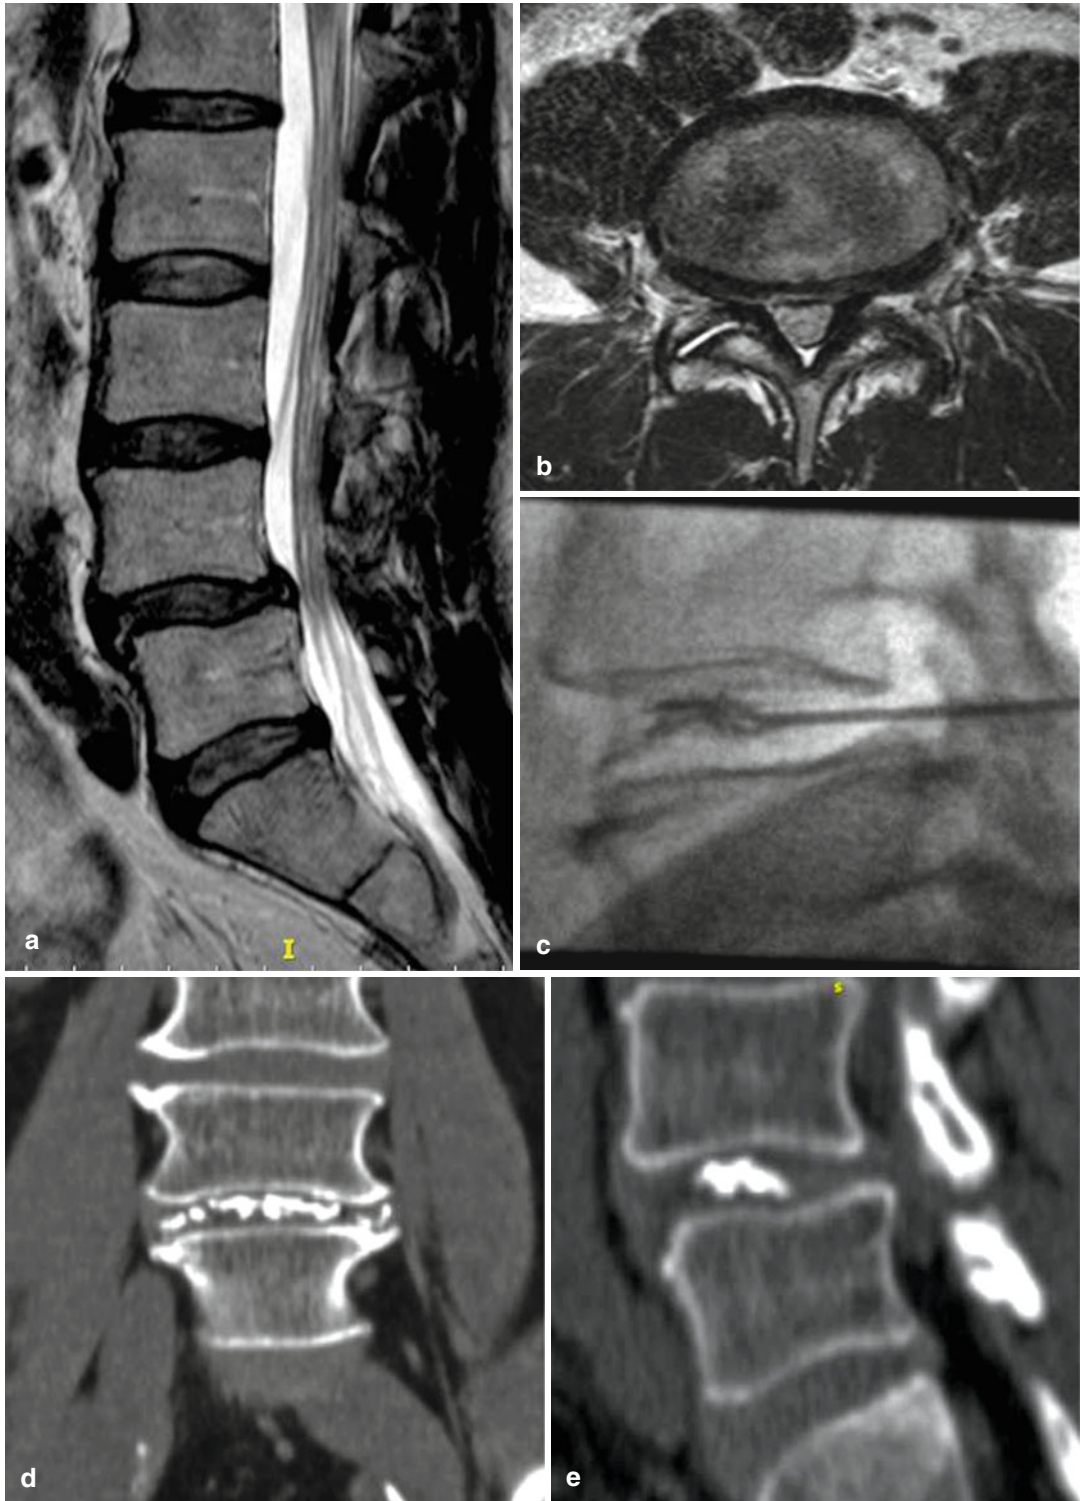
L4–L5 intradiscal Discogel injection for the treatment of discogenic pain due to intervertebral disc degeneration and herniation. (a, b) Midsagittal T2-weighted MR image (a) shows degenerative disc changes with low signal intensity of the lower lumbar discs and central
